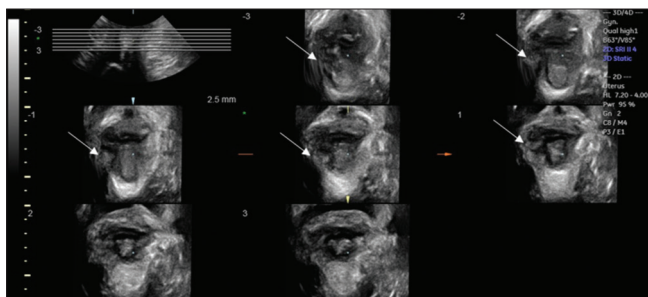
Transperineal three-dimensional ultrasound using tomographic ultrasound imaging for pelvic floor muscles in contraction performed before physiotherapeutic treatment shows a complete right-sided trauma (left on image, indicated by the white arrow) visible in all tomographic slices 2.5 mm above the plane of minimal dimensions
